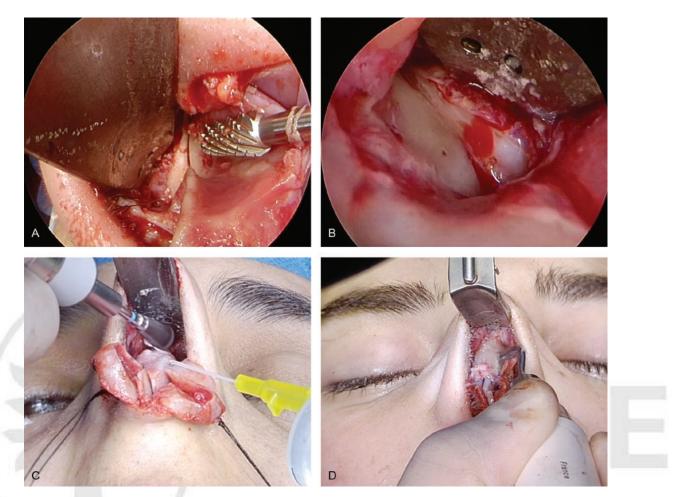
Refinements in dorsal preservation rhinoplasty. (A) A step at the right nasofacial groove can be seen; a cylindrical burr will be used; (B) Smooth transition at the left nasofacial groove after it has been corrected; (C) Sculpting S-shaped nasal bones; (D) Paramedian osteotomies with an ultrasound device to narrow the bony vault.
